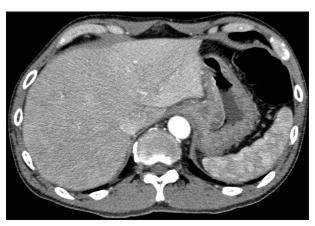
Computed tomography scan showed a large, hypo-dense, tumor-like lesion just below the stomach cardia
